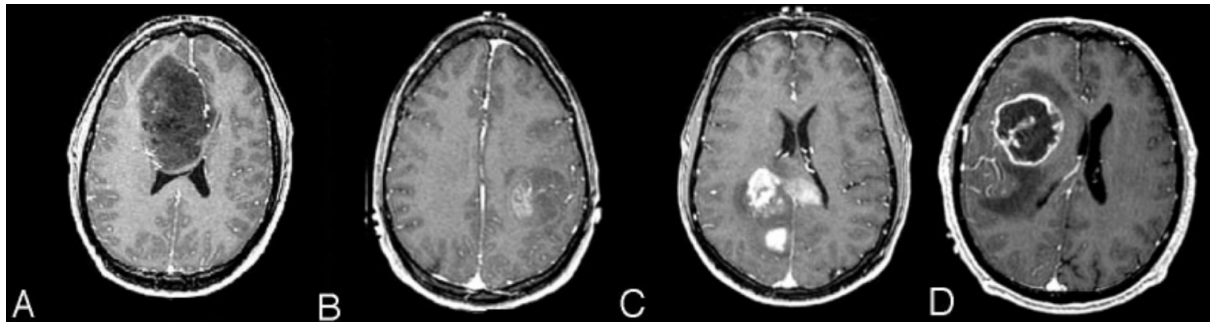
MRI scans of various brain tumours; A: Grade II Astrocytoma, B: Grade III Astrocytoma, C: Grade IV Astrocytoma and D: Glioblastoma Multiforme. Adapted from ref [66].
